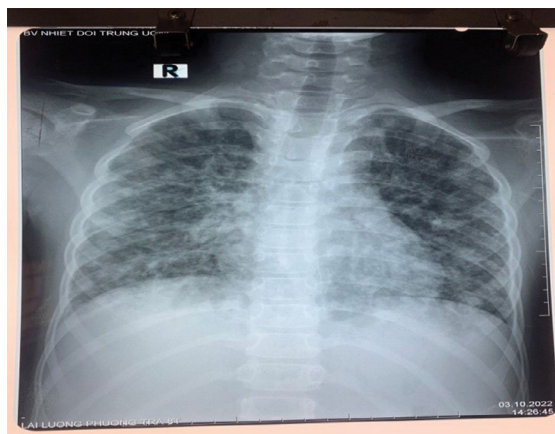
X-ray of the lungs (Oct 3.2022)
